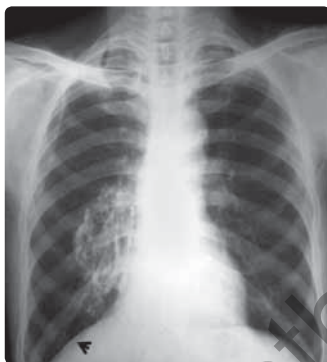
Chest X-ray PA view showing right sided pleural calcification and calcification of right diaphragmatic pleura (arrowhead)
